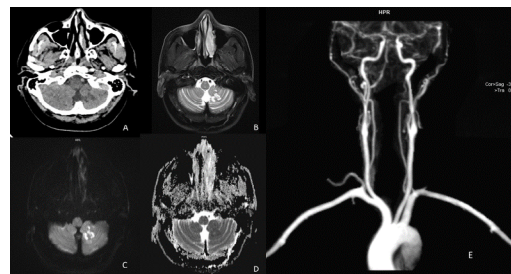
Vertebrobasilar artery infarct. Area of hypodensity noted in axial NCCT head (a) appearing hyperintense on T2 (b) and showing diffusion restriction on DWI (c) and ADC (d) MR angiography shows complete non-visualisation of left vertebral artery
